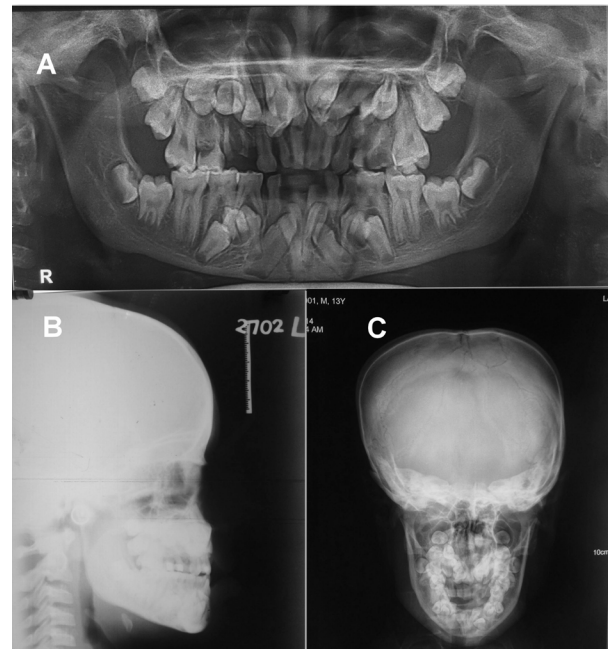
Radiographs showing dental abnormalities (A), OPG shows supernumerary teeth, multiple impacted teeth and over retained primary teeth. (B), Lateral view of skull shows broad sutures and wormian bones. (C), Anteroposterior view of skull showing sunken sutures and depressed calvaria.
